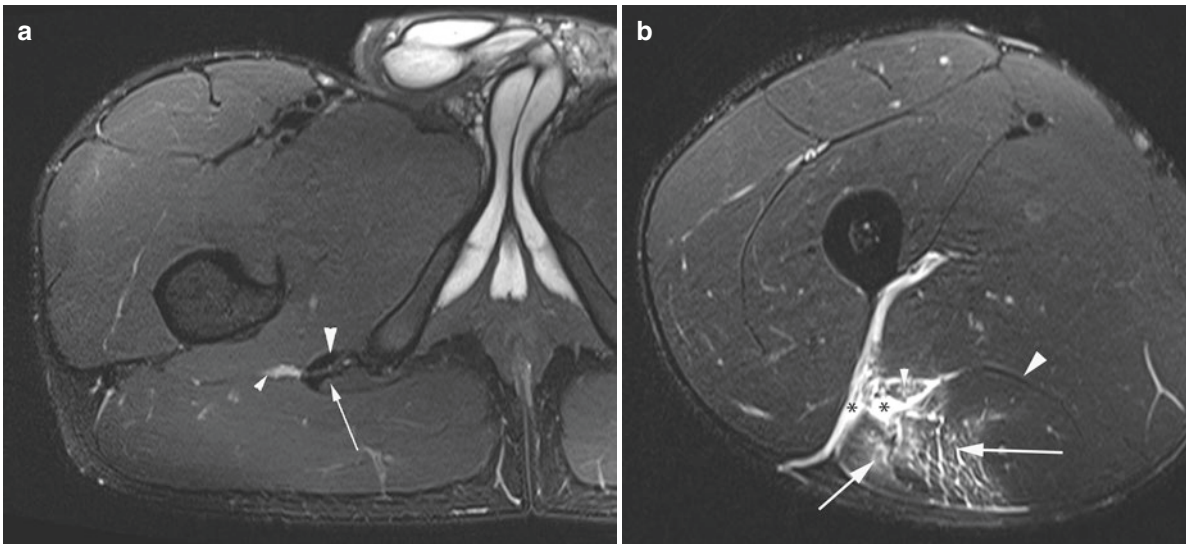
Myotendinous injury. A 24-year-old soccer player with acute hamstring pain. Axial T2FS MR images show (a) right proximal thigh with normal conjoint tendon (arrow), semimembranosus (large arrowhead), and sciatic nerve (small arrowhead) and (b) semitendinosus and biceps femoris myotendinous tear with tendon involvement (arrows) with decompressed hematoma (asterisk) around the sciatic nerve (small arrowhead) and fascia. Normal semimembranosus (large arrowhead)
